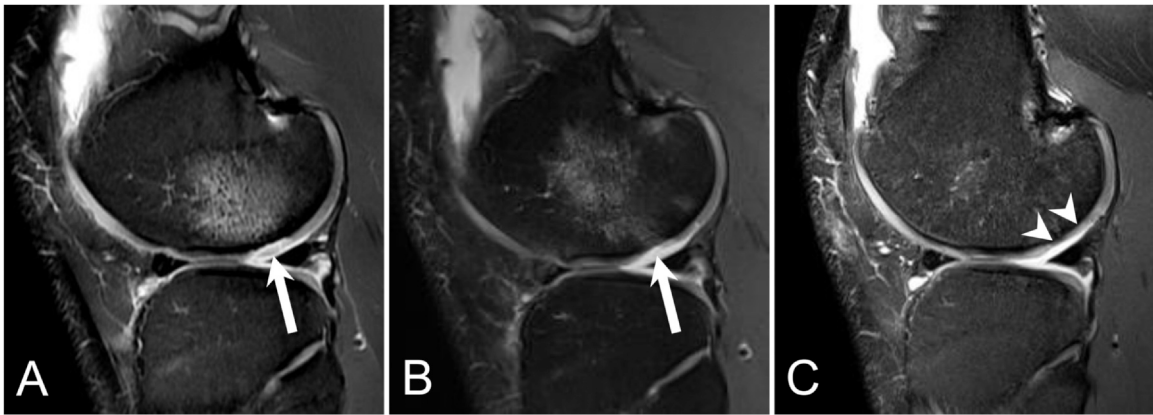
Elite hockey player presents for MRI immediately following a noncontact knee injury. Sagittal PD FS MR image (A) through the lateral compartment demonstrates an acute osteochondral injury with a high-grade cartilage defect and adjacent delamination at the posterior weight-bearing surface of the lateral femoral condyle (arrow). Sagittal PD FS MR image (B) of the knee obtained 2 months later demonstrates interval improvement of the subchondral bone marrow edema but slight interval progression of the high-grade cartilage lesion (arrow). Sagittal PD fat-suppressed MR image (C) from an MRI performed 8 months after the initial injury demonstrates interval postsurgical changes of microfracture with moderate ingrowth of fibrocartilage (arrowheads) and interval resolution of the subchondral bone marrow edema. FS, fat saturation; MR, magnetic resonance; MRI, magnetic resonance imaging; PD, proton density.
